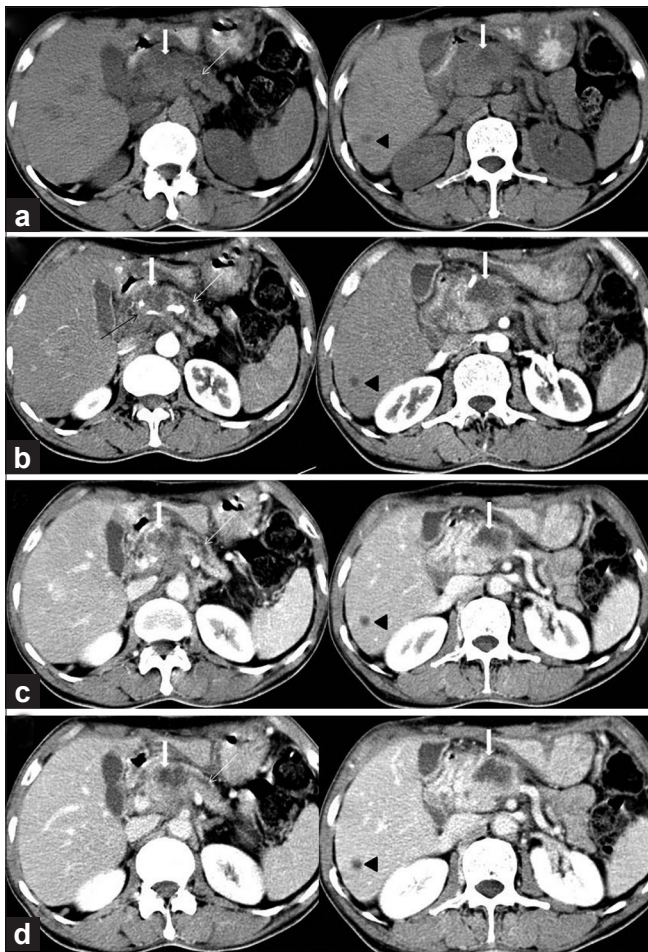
Pancreatic adenocarcinoma. Axial plain (a) and triple-phase contrast-enhanced CT upper abdomen obtained in arterial (b), pancreatic parenchymal (c) and portal venous (d) phase, in a 70-year-old male who presented with severe abdominal pain, demonstrates an ill-defined nonenhancing hypodense mass involving the head and proximal part of body of pancreas (thick vertical white arrow). Peripancreatic extension with encasement/attenuation of celiac axis branches (thin black arrow), infiltration and dilatation of main pancreatic duct (thin white arrow) and liver metastases (black arrow head) are also evident which make the tumor unfit for resection. Note that the pancreatic and portal venous phases are best for tumor detection, the hypovascular metastases stand out best in portal venous phase, while the arterial phase is good for demonstration of celiac axis encasement
